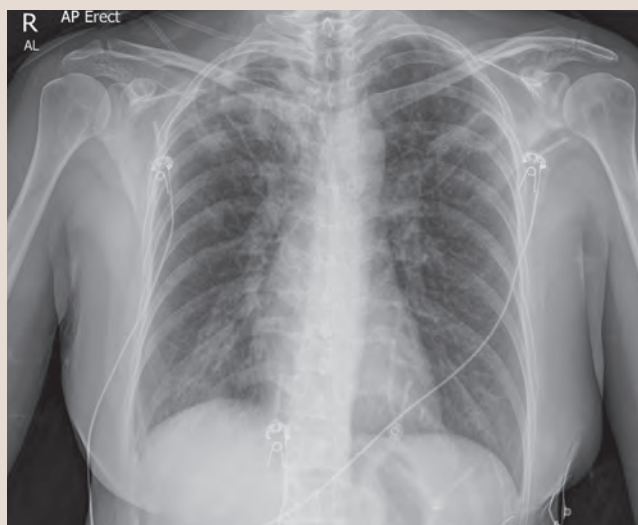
Chest x-ray showing extensive bilateral upper lobe cavities and multinodular consolidation throughout both lungs.
